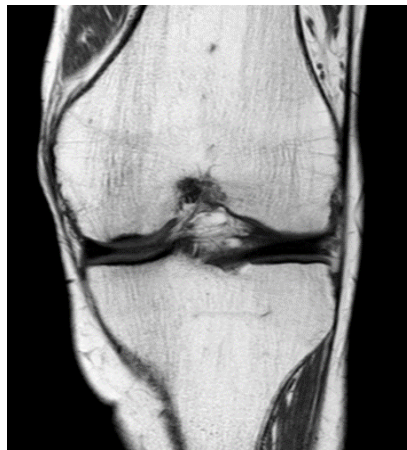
T1-weighted MRI, medial femoral ON
